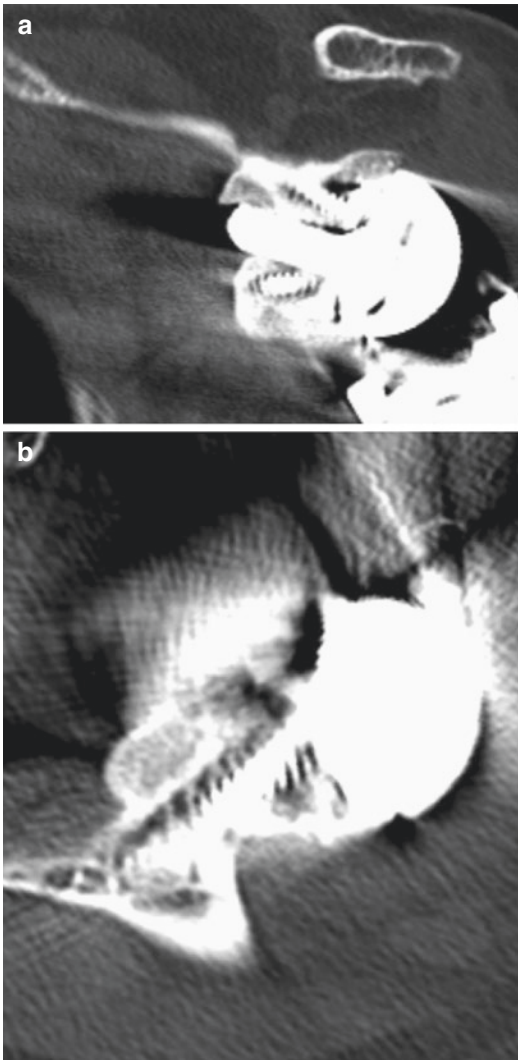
These coronal (a) and axial (b) computed tomographic images demonstrate a completely incorporated femoral head allograft placed using a BIORSA technique
